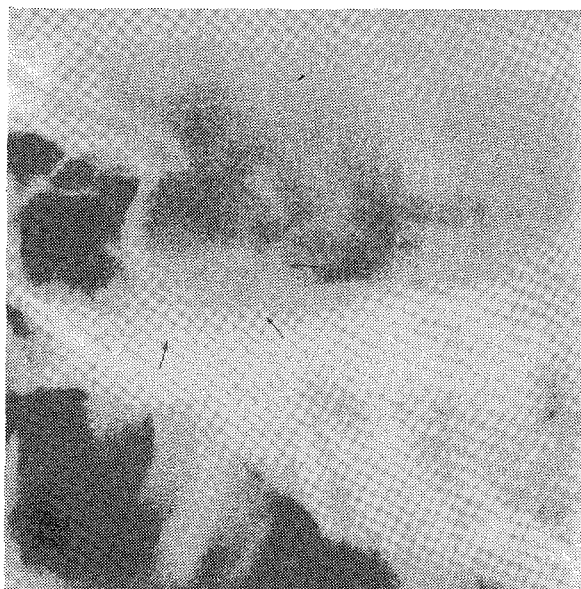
Lateral skull X-ray (cone view) showing enlarged and eroded pituitary fossa of patient MC.
